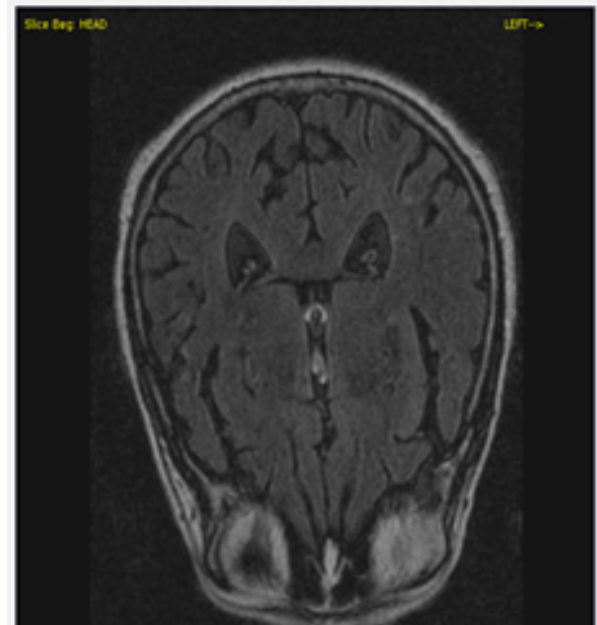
FLAIR Image of an MRI scan of a patient with enlarged Virchow-Robin Spaces. Presence of some spaces is normal particularly in participants of the Original Cohort (1948).
